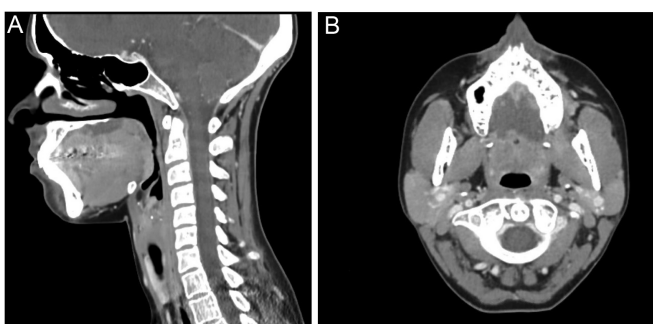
Sagittal (A) and axial (B) CT images show a sharply delineated, highly irregular hypodense zone in the palate.
